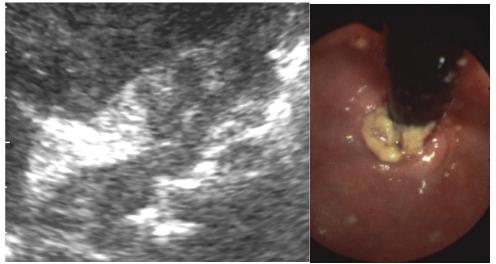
a, b Parietal hypertrophy and lymphatic metastasizing oesophagus tumour (history of "deep" dysphagia) (clinical cancer confirmed by sonography guided puncture cancer); UAS longitudinal
